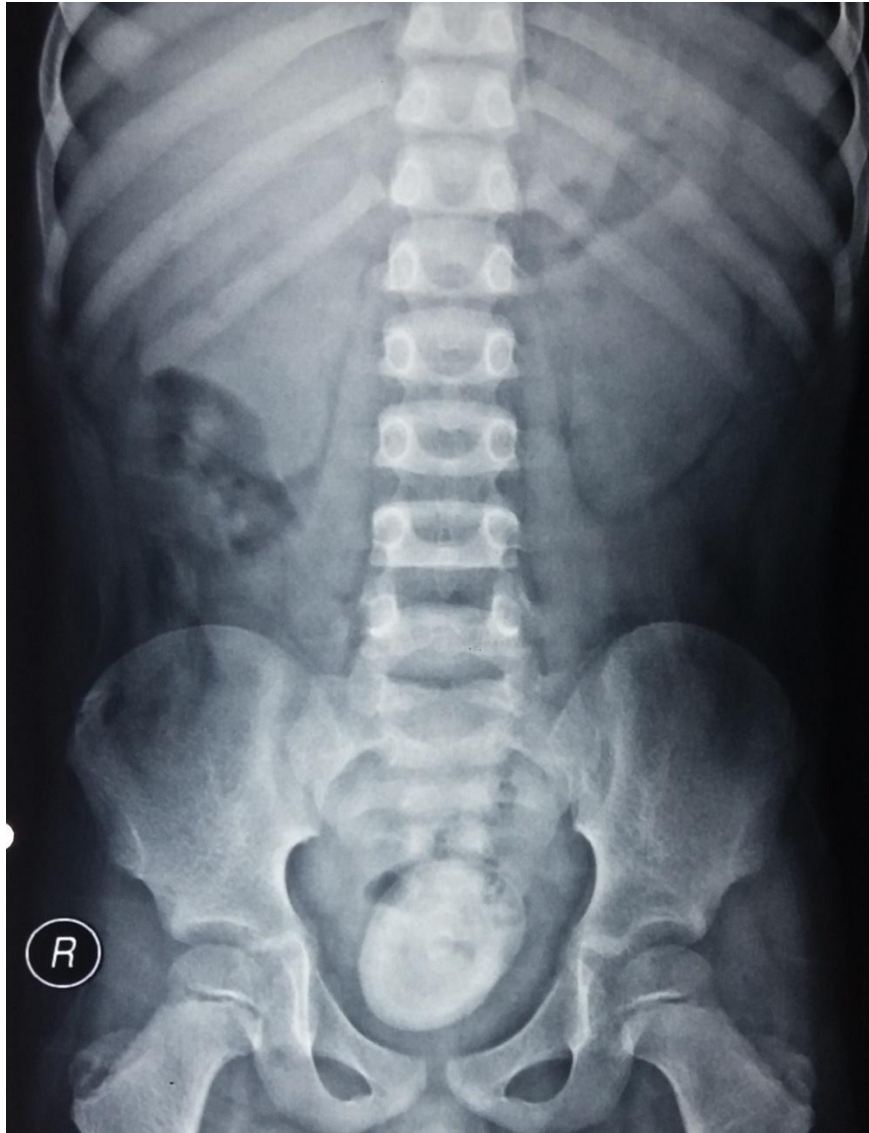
X-ray KUB showing large bladder stone
